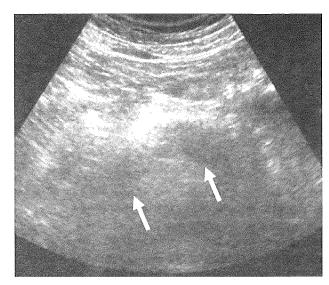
Abdominal ultrasonography in AIP (multiple mass forming). Low echoic masses were observed in the pancreas head and body (arrows)
